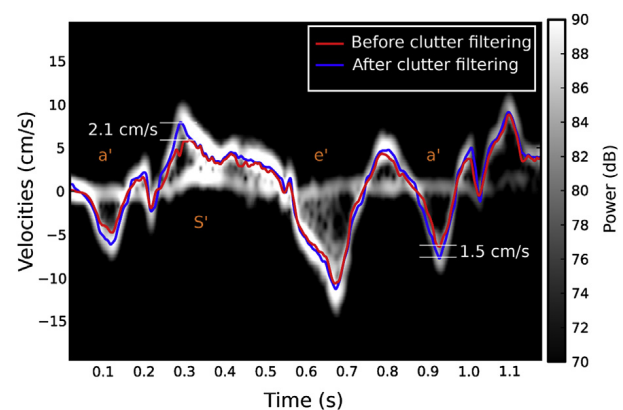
Velocity curves before and after clutter filtering, in a Doppler spectrum from the basal septum. The spectrum shows clutter noise around the baseline. In this example, the effect of the clutter filter is most evident in the  $S'$  and  $a'$  waves.
